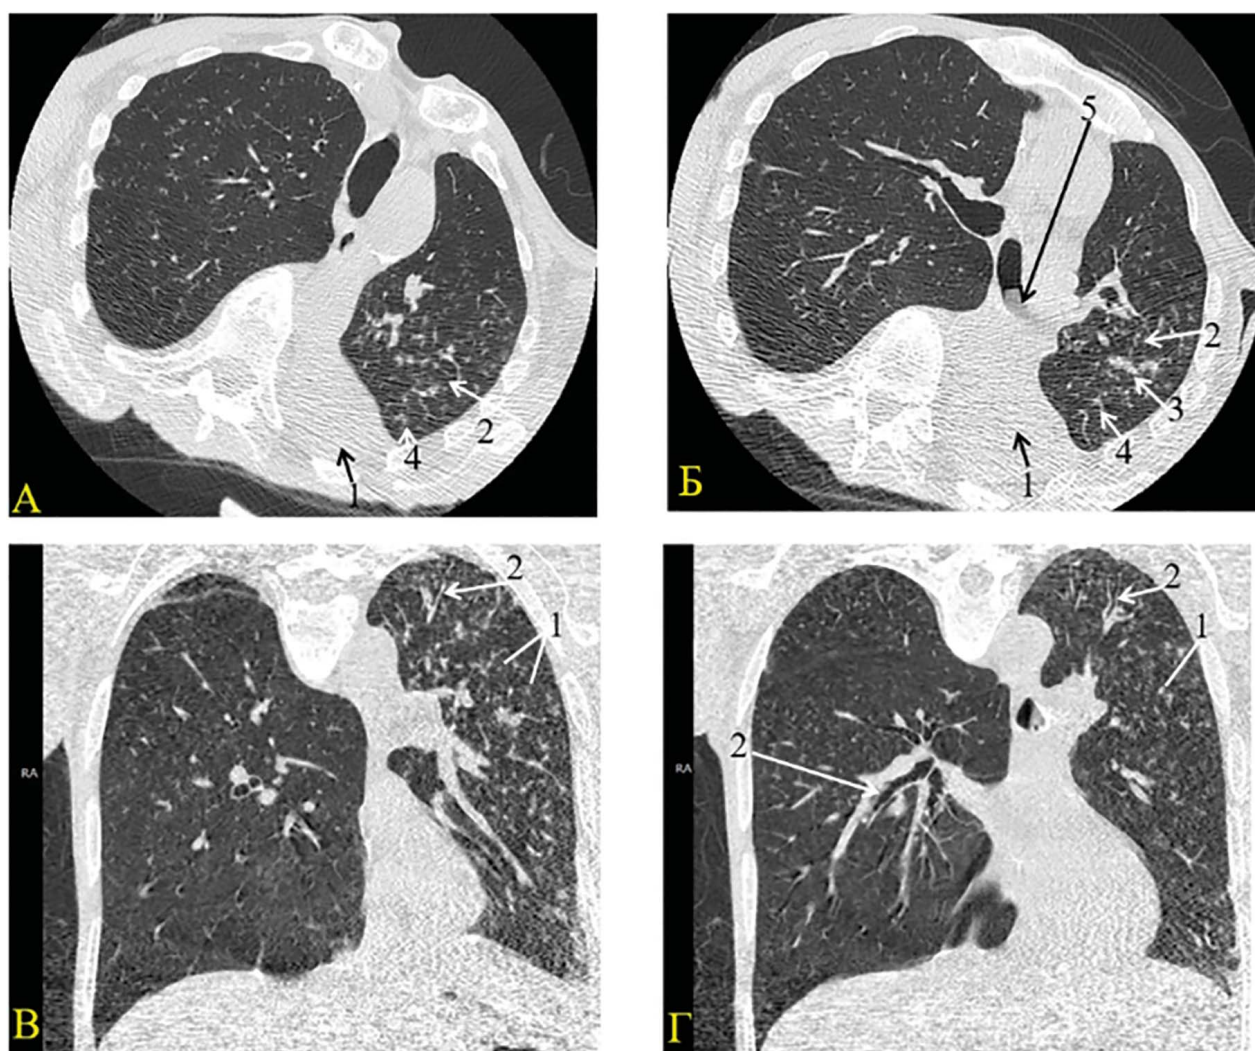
CT of a 59-year-old woman with aspiration bronchiolitis. The patient has left-sided spastic hemiplegia, pseudobulbar syndrome, symptomatic epilepsy as a result of an ischemic stroke
